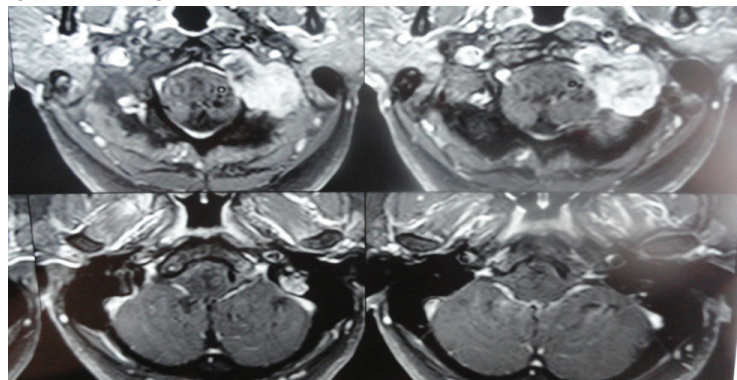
Contrast enhanced MRI of the brain showing an homogeneously enhancing extraaxial tumor in the region of jugular bulb
